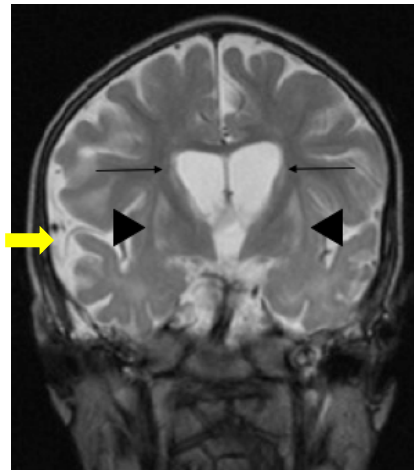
T2 weighted MRI at 39 months of age. Bilateral symmetrical signal abnormality of putamen (black arrowheads) and caudate (black arrows) is seen in addition to cerebral atrophy, indicated by increased extra-axial spaces (yellow arrow). Adapted from McTague et al, *Brain* 2013;136:1578-91.
